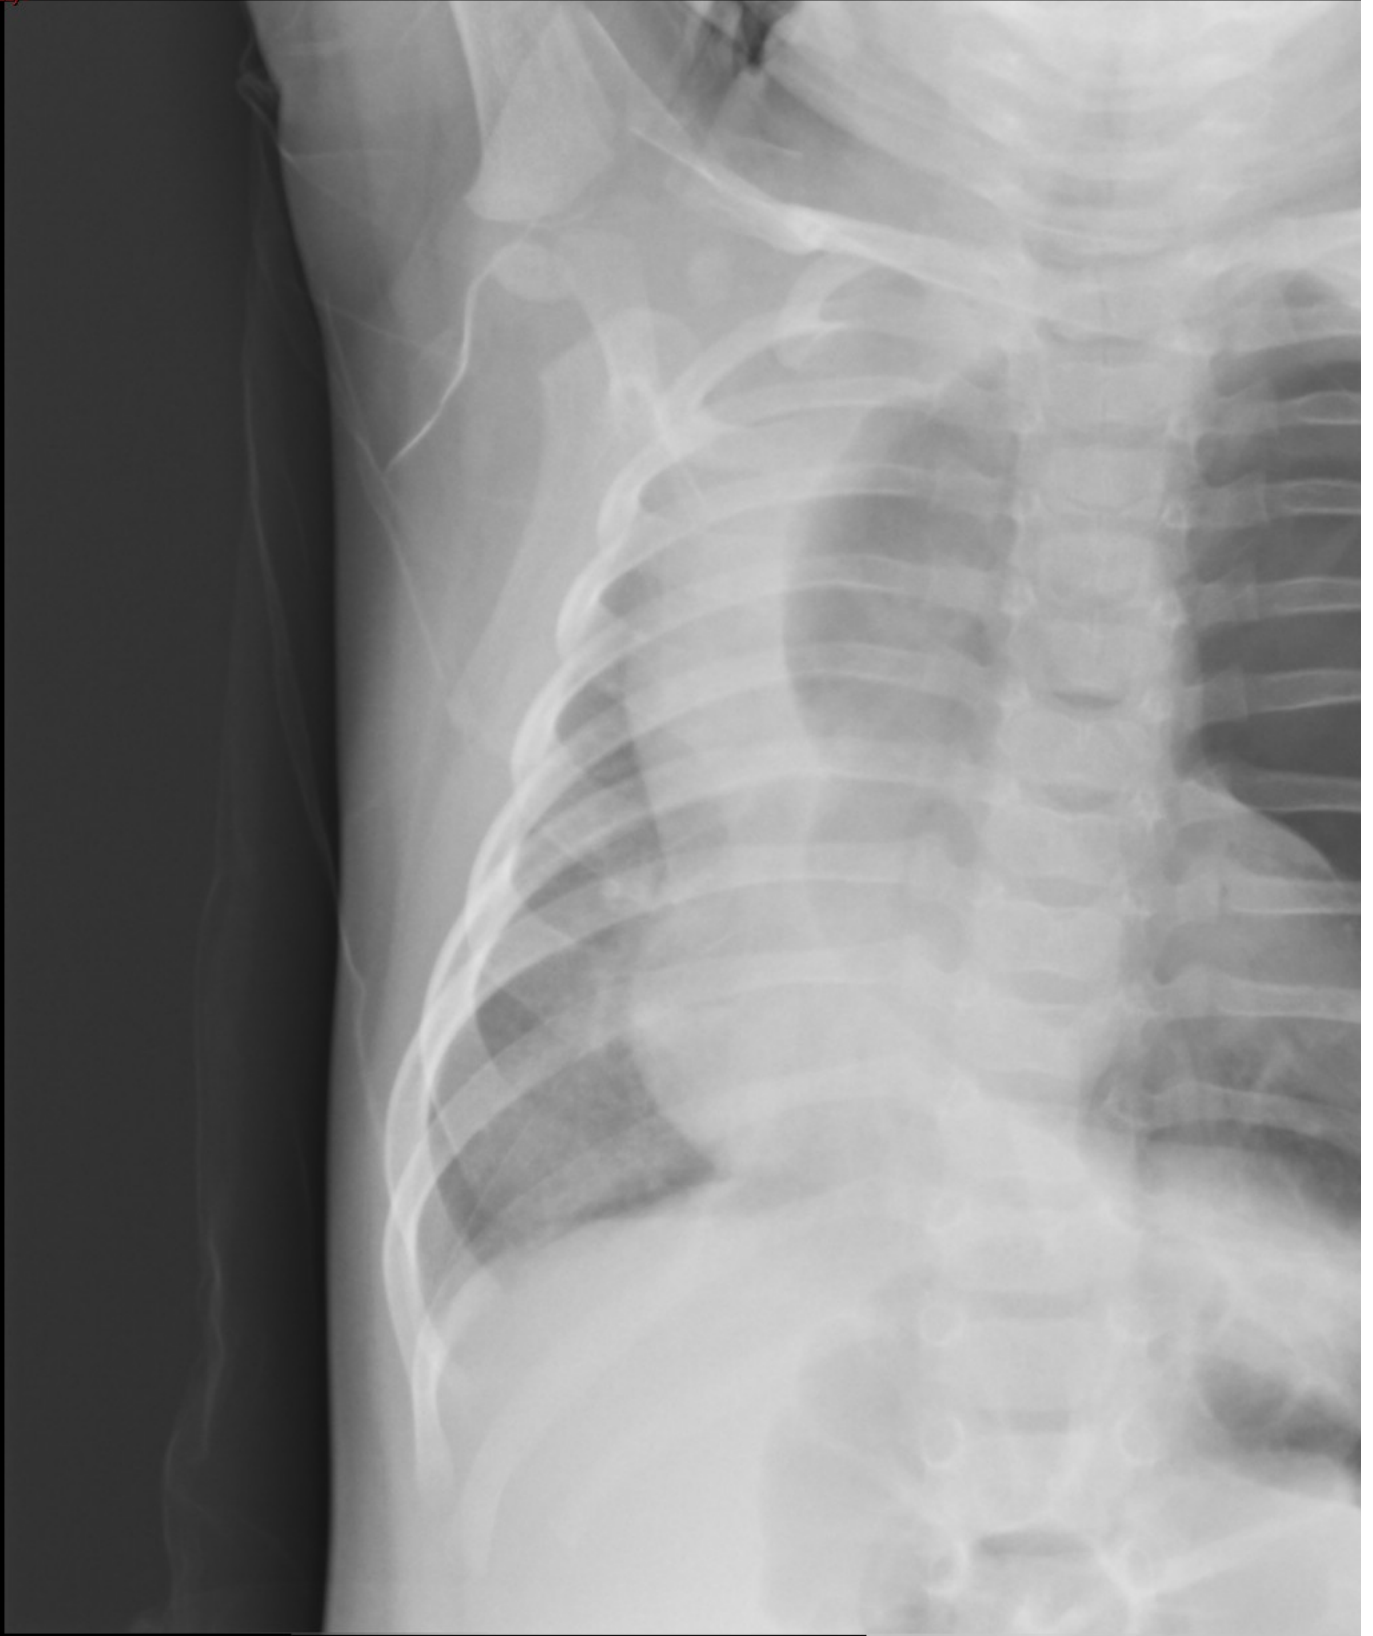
Chest radiograph of patient in vignette.
